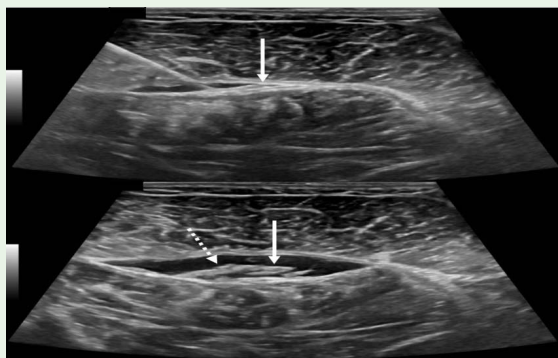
Transverse calf ultrasound images during medial calf aponeurotic adhesiolysis. Top image showing early hydro-dissection of the scar on the left with the needle medial to the plantaris tendon (arrow) that is hypoechoic relative to the scar. Bottom image showing completed adhesiolysis of the plantaris tendon (arrow) from the MHG and soleus aponeuroses. There is a dense band of scar tissue (dotted arrow) extending between the plantaris tendon and the soleus aponeurosis.
